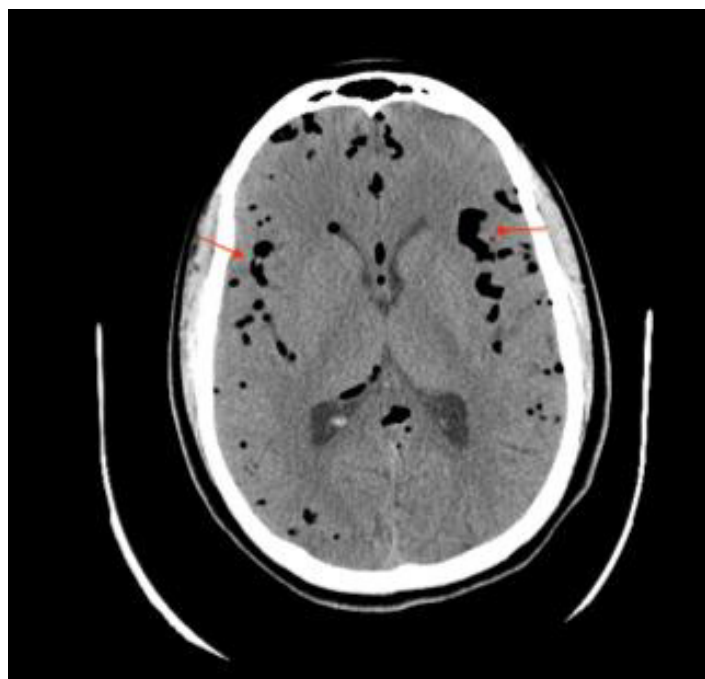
Axial view from head computed tomography without contrast demonstrating subarachnoid air. Red arrows indicate collections of hypoattenuation, representing air in the subarachnoid space.
